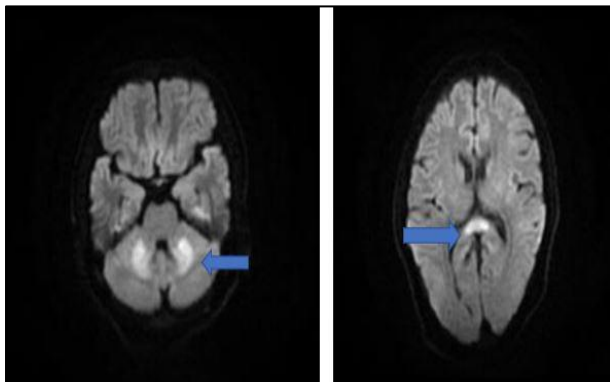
Axial T2W MRI of brain shows new symmetric areas of hyperintensity involving dentate nuclei (arrow) and resolving lesion of splenium of corpus callosum (arrow head).
